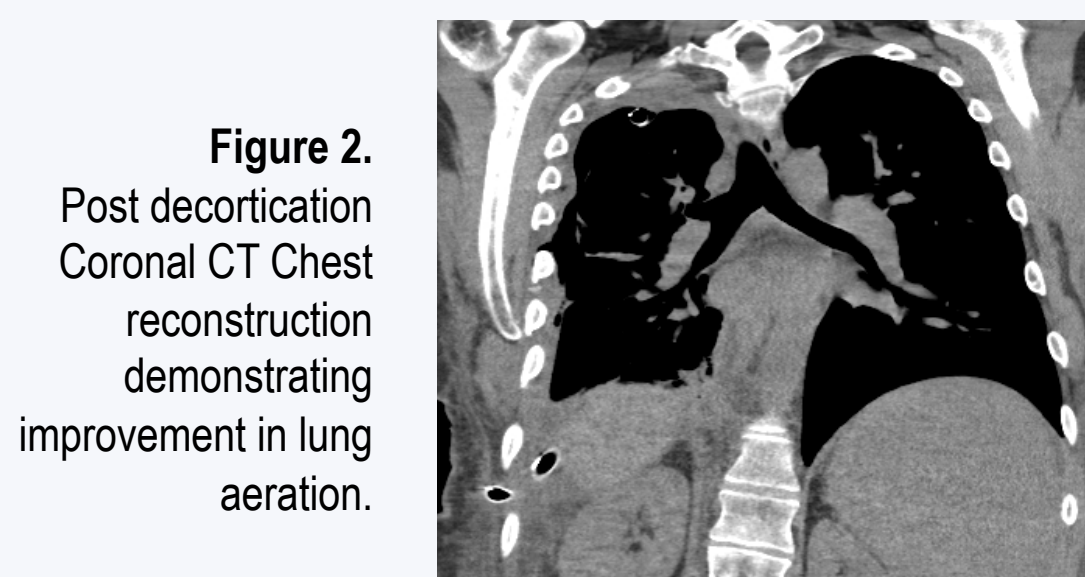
Post decortication Coronal CT Chest reconstruction demonstrating improvement in lung aeration.
